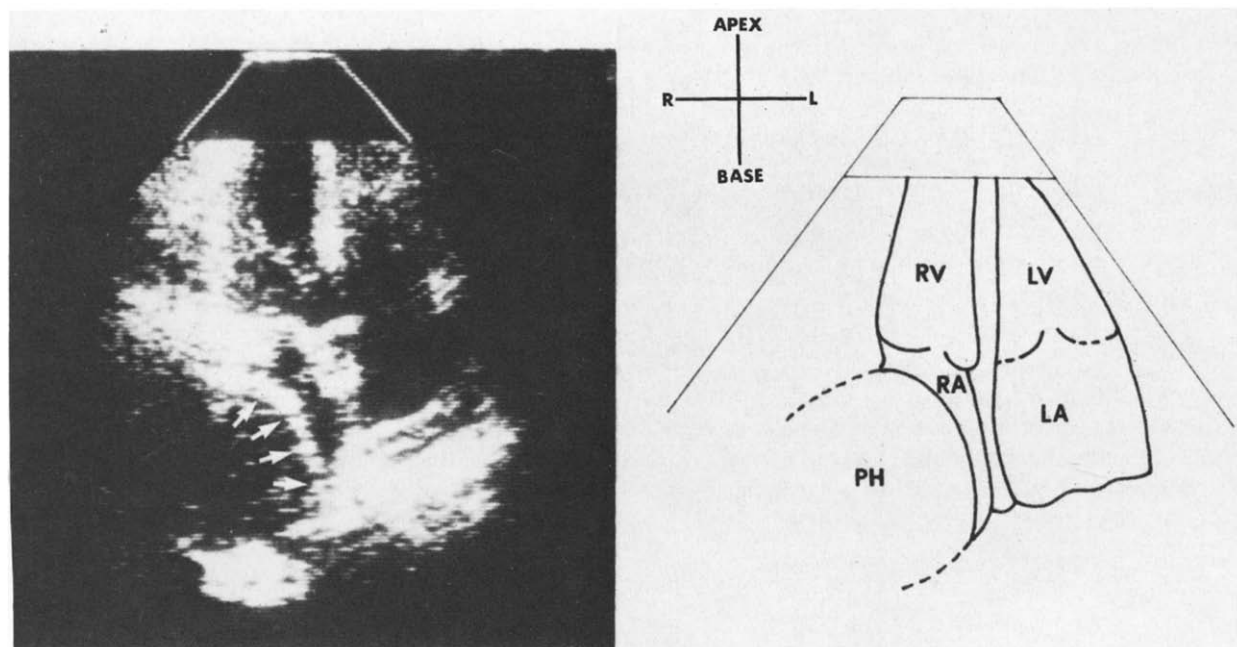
Apical four chamber view of two-dimensional echocardiogram showing a large pericardial hematoma (PH) compressing the right side of the right atrial wall (arrows). Note the slit-like appearance of the right atrial cavity (RA). L = left; LA = left atrium, LV = left ventricle, R = right; RV = right ventricle.
